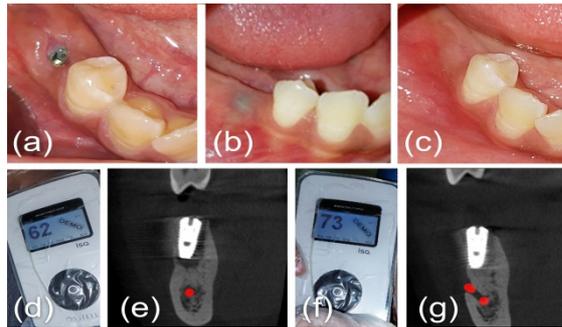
clinical and radiographic evaluation. (a,b,c) showing EHI at 2, 4 and 8 weeks. (d,e) showing ISQ values and a CBCT radiograph immediately postoperative. (f,g) showing ISQ values and a CBCT radiographic at 6 months follow up.
